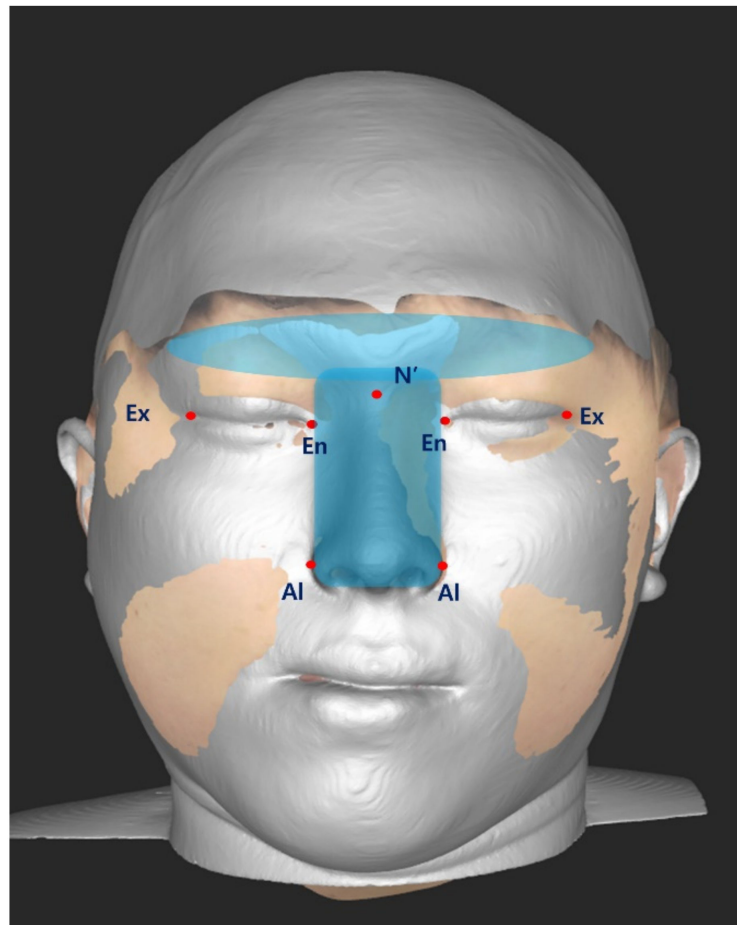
Registration of preoperative (T1) CT and FS images. The references used for superimposition were the forehead and the dorsum of the nose area (blue color), exocanthions, endocanthions, and nasal alas: N', soft tissue nasion; Ex, exocanthion; En, endocanthion; Al, nasal ala; CT, computed tomography; and FS, facial scanner.
